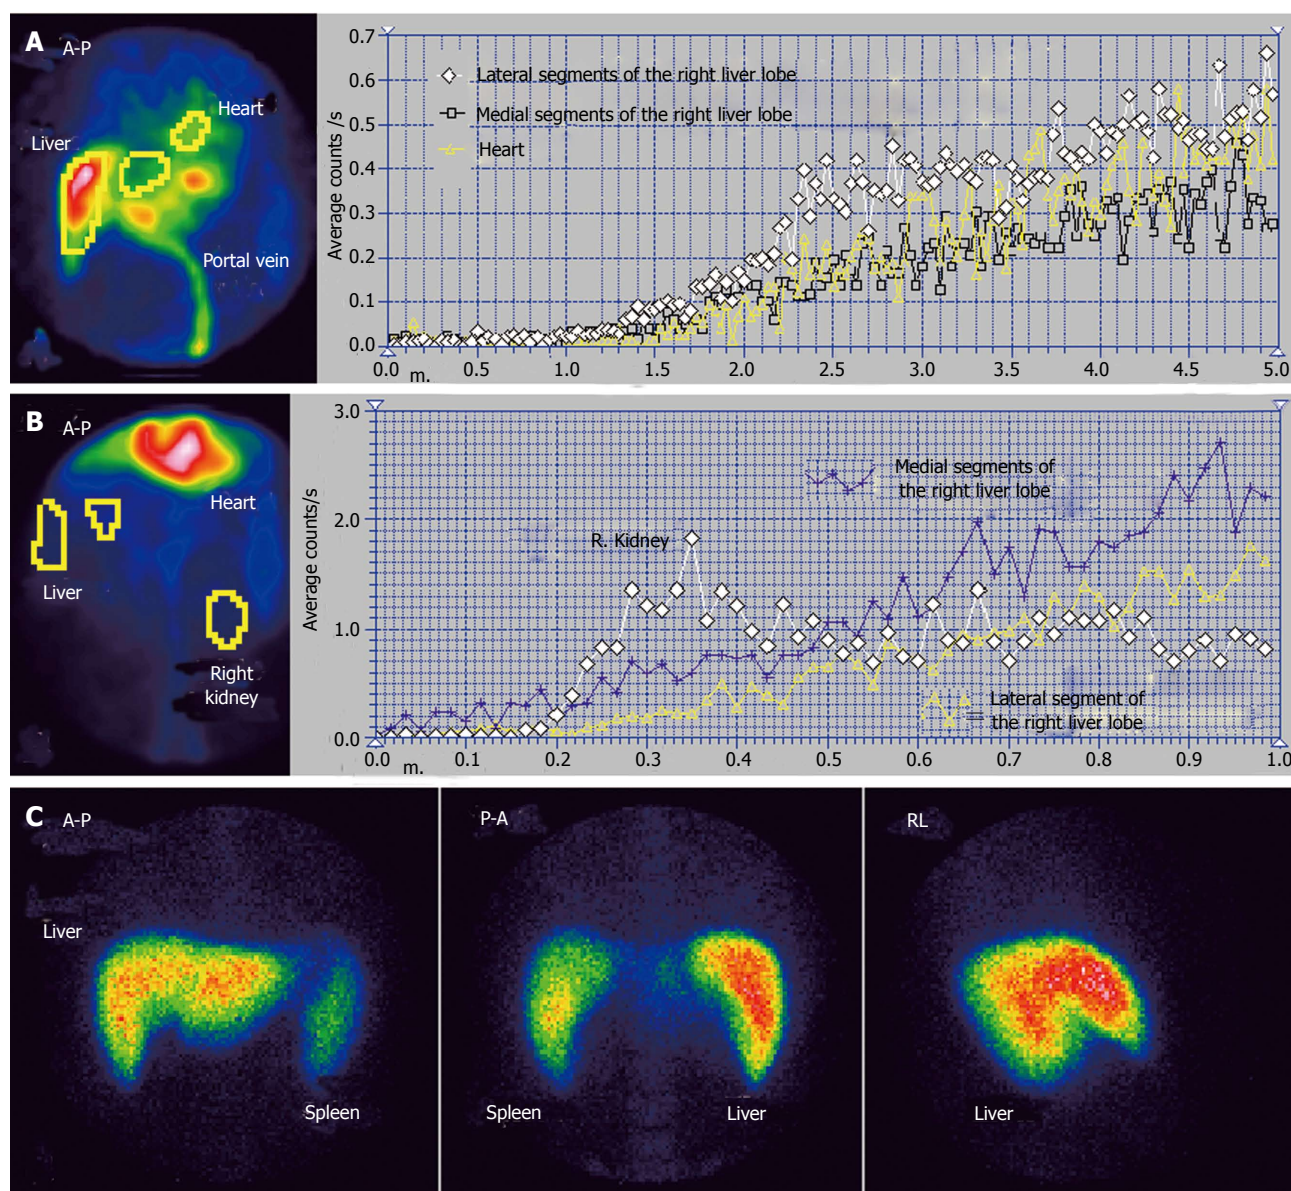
Budd-Chiari syndrome with obstruction of the middle hepatic vein. A: Per-rectal portal scintigraphy; B: Liver angioscintigraphy; C: Liver scan.
